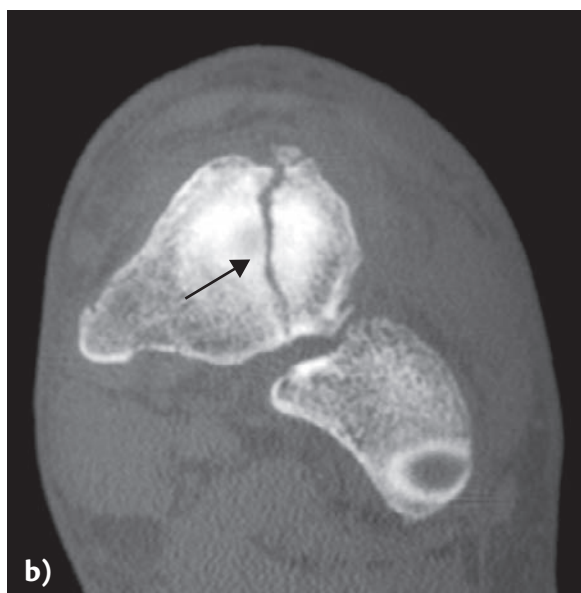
Stress fracture of the navicular bone in the foot. a) Point of navicular tenderness locally; b) computed tomography shows a stress fracture of the navicular bone (arrow). (Courtesy of Prof. Lars Engebretsen, University of Oslo, Norway.)
